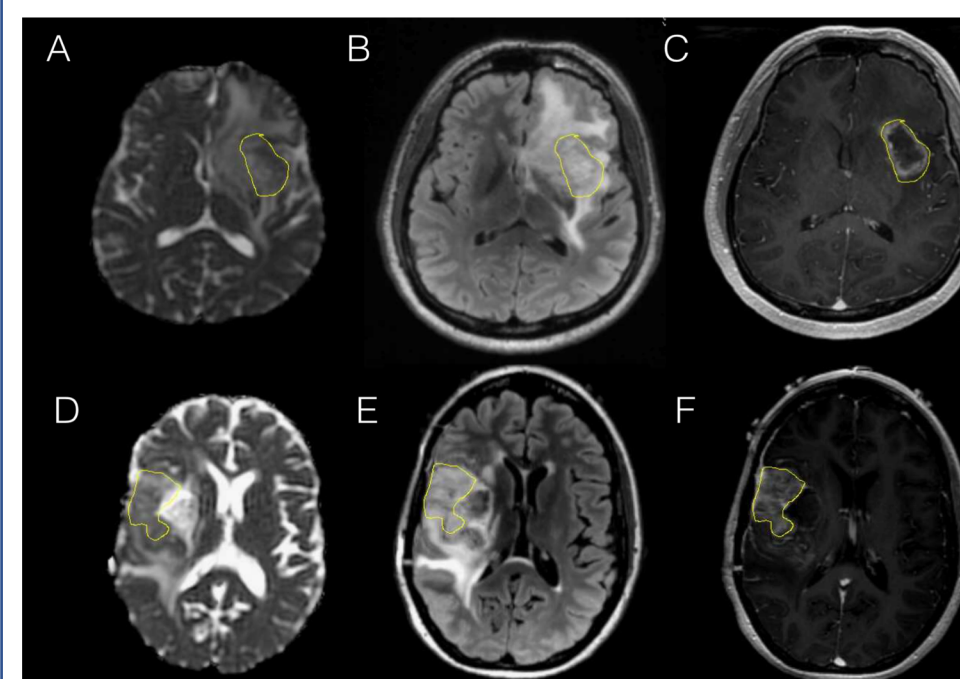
Comparison of ADC images from DTI among treatment effect (A-C) and true recurrent HGG (D-F). Yellow lines delineate T1 contrast enhanced (CE) ROIs. ADC in TxE (A) shows minimal decrease near CE, whereas ADC in rHGG shows significant decrease relative to (A). T2w FLAIR images (B, E) depict hyperintense regions around the CE from T1. T1w gadolinium injected images (C-F) depict regions of CE.
